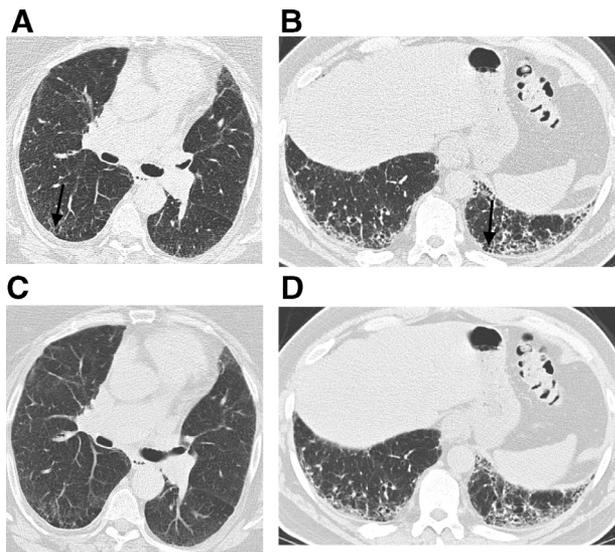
Thin (1 mm) thick axial images (A, B) reconstructed from HRCT demonstrate mild peripheral reticulation and mild subpleural honeycombing (arrows). Honeycombing is obscured by volume averaging on thicker (3 mm) reconstructed images (C, D).
